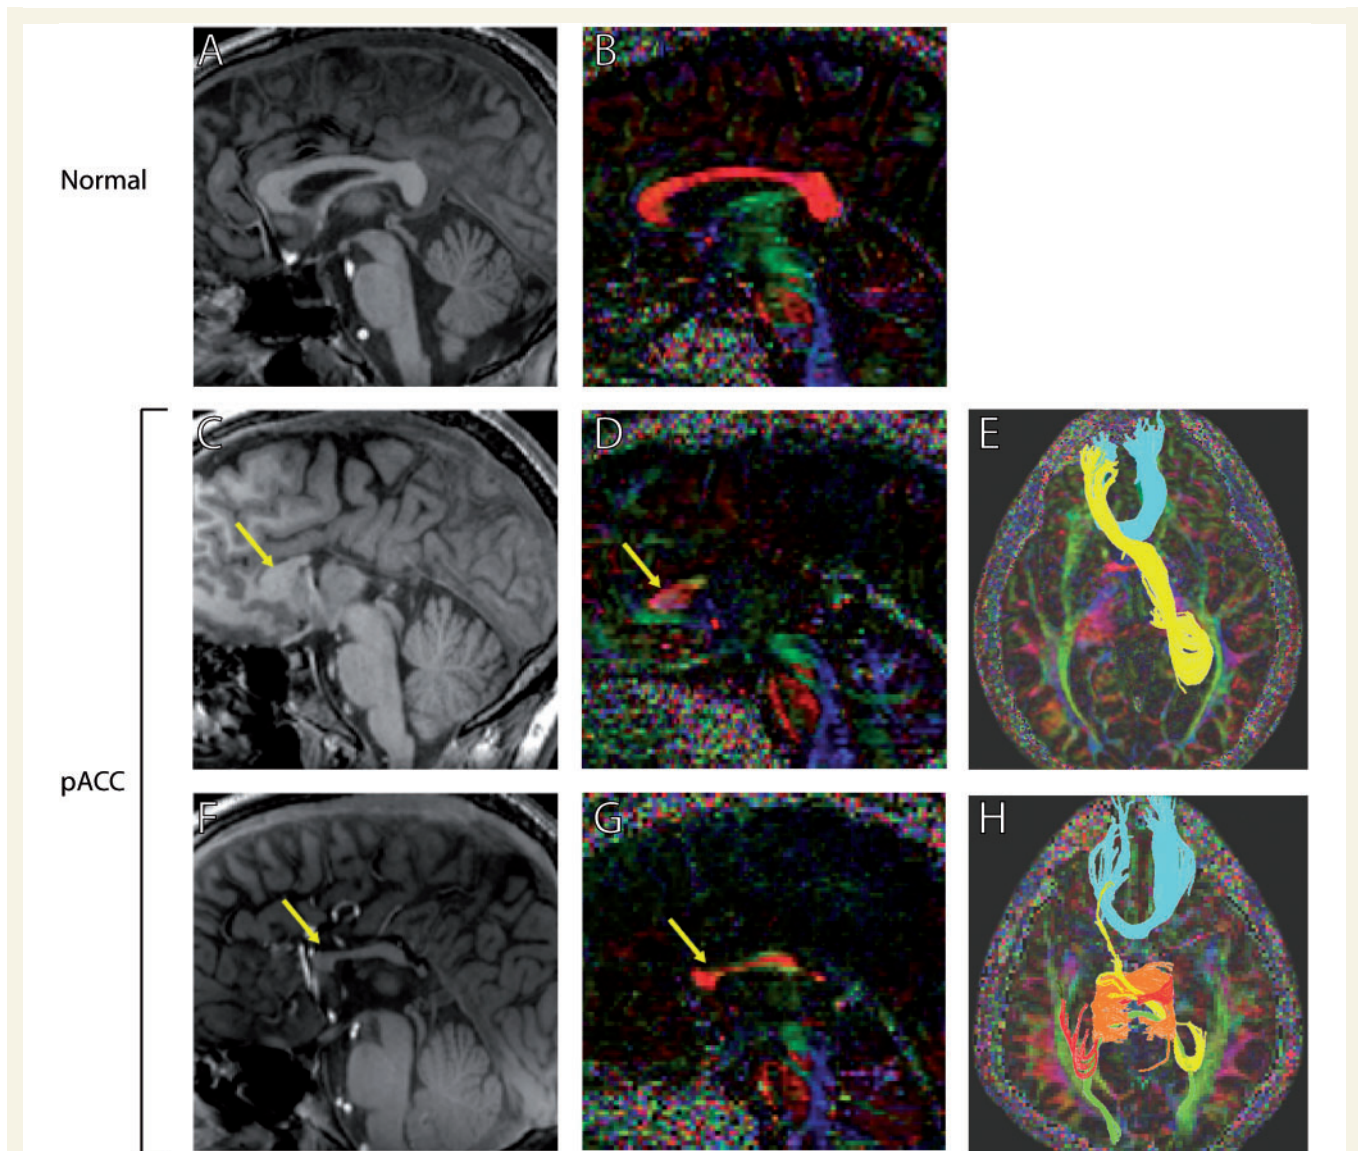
T₁-weighted midsagittal MRI and diffusion tensor imaging tractography of two patients with partial ACC (pACC) and a normal corpus callosum control. (A, C and F) T₁-weighted midsagittal MRI scans. (B, D and G) High-angular-resolution diffusion imaging. Arrows indicate callosal fragments present in partial patients with ACC. (E and H) Q-ball tractography of partial patients with ACC reveals callosal connections between homotopic and heterotopic cortical regions. Homotopic connections between anterior frontal lobes are conserved in both partial patients with ACC (blue streamlines in E and H; orange streamlines in H), but the degree of temporal and occipital connectivity varies. Both patients also show 'sigmoid bundles' (yellow streamlines in E and H), which connect the anterior frontal lobe with the contralateral parieto-occipital region. Images adapted from Wahl *et al.* (2009).
